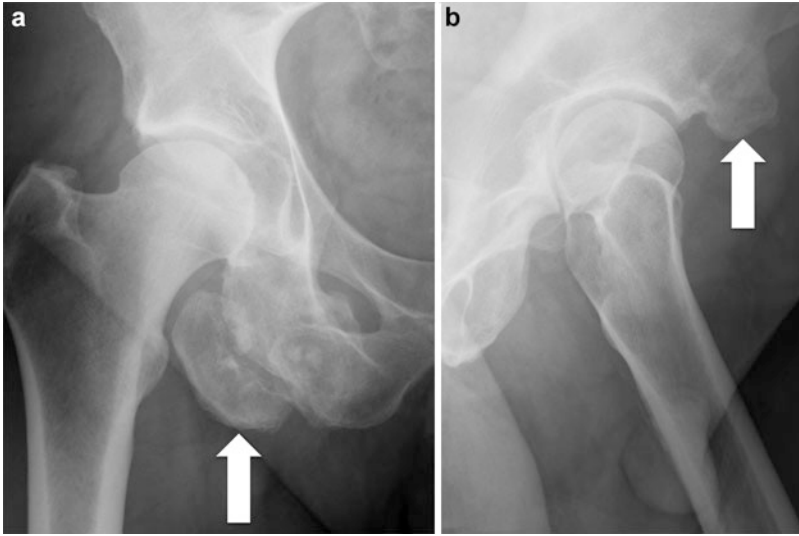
(a) AP radiograph of the right hip demonstrating extensive heterotopic ossification at the origin of the hamstring tendon complex (*arrow*), likely from a chronic avulsion injury. (b) Lateral false-profile radiograph of the left hip demonstrating prominence of the left anterior inferior iliac spine (AIIS—*arrow*), likely from a remote avulsion injury. This bony prominence may lead to subspine impingement between the proximal femur and the AIIS
